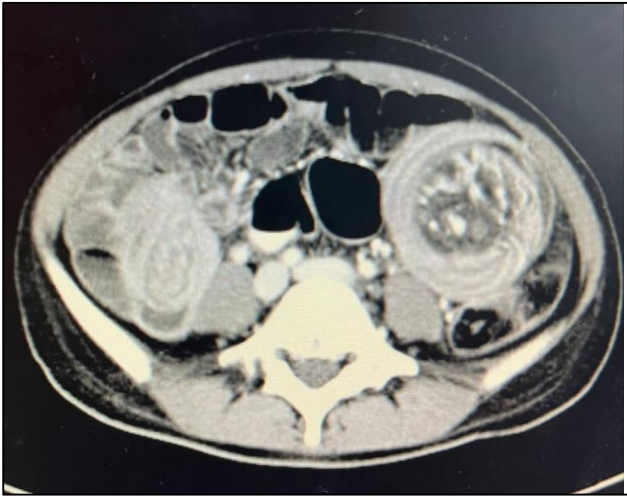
Axial section of CT abdomen and pelvis demonstrating intussusception.
